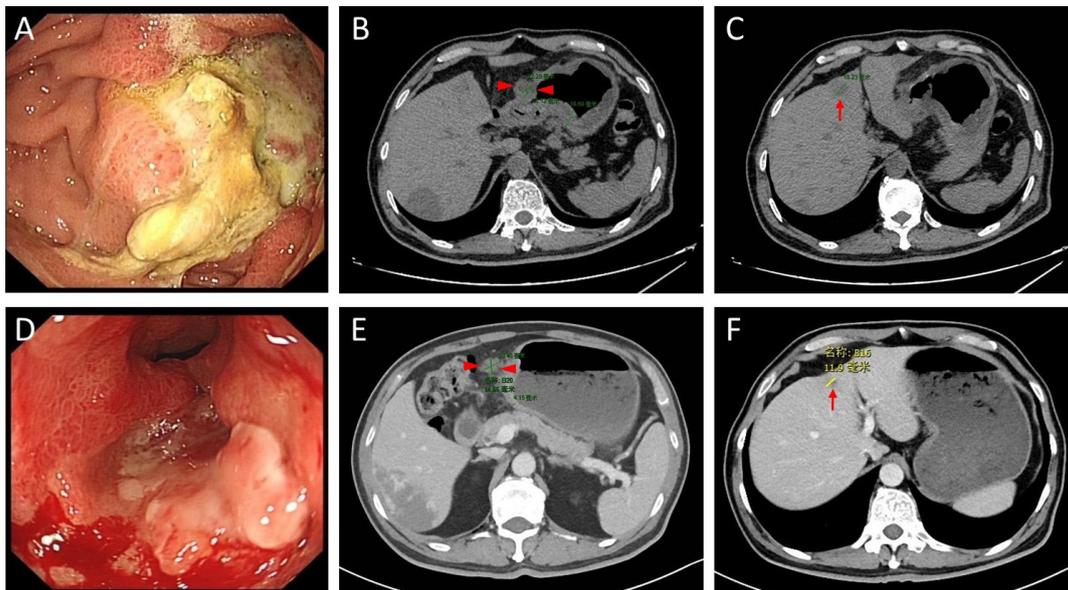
Gastroscopy and CT images of patient 2 before and after treatment of combination regimens. Cancerous ulcers in the body of the stomach (A), a 22.28 mm ×22.12 mm perigastric lymph node metastasis (red arrowheads), thickened gastric wall (B) and liver metastases (red arrow) (C) could be observed before treatment. After 5 cycles of treatment, cancerous ulcers disappeared largely (D), the perigastric lymph node metastasis shrank to 20.48 mm ×14.66 mm (E), and one case of liver metastasis shrank (F). CT, computed tomography.
